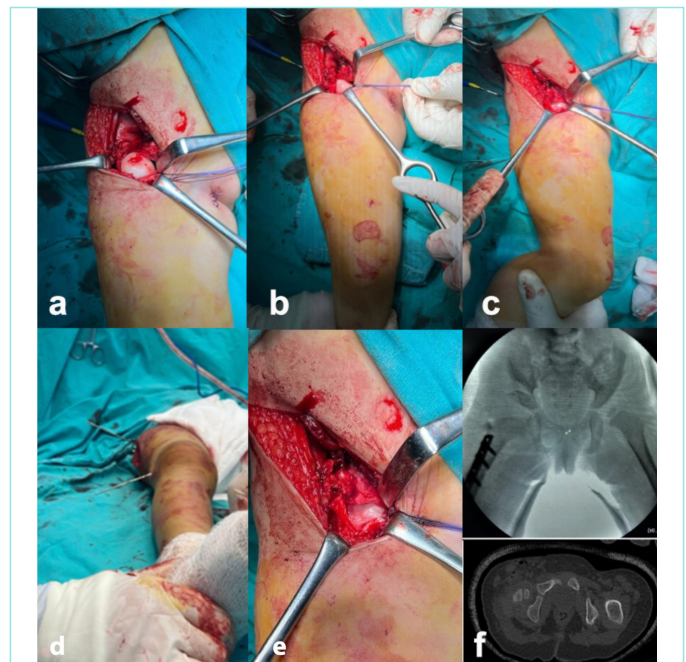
a) View of aspheric femoral head after capsulotomy, b) After pelvic osteotomy, the view of joint incompatibility while the leg is in flexion, abduction, and neutral rotation, c) the joint appears to be maximally compatible when the leg is in flexion, abduction, and internal rotation, d) determination of the degree of derotation between two Kirschner wires after femoral osteotomy, e) the appearance of the joint after fixation of the osteotomy area with a semitubular plate after derotation, f) postoperative pelvic X-ray and CT image of the patient.
